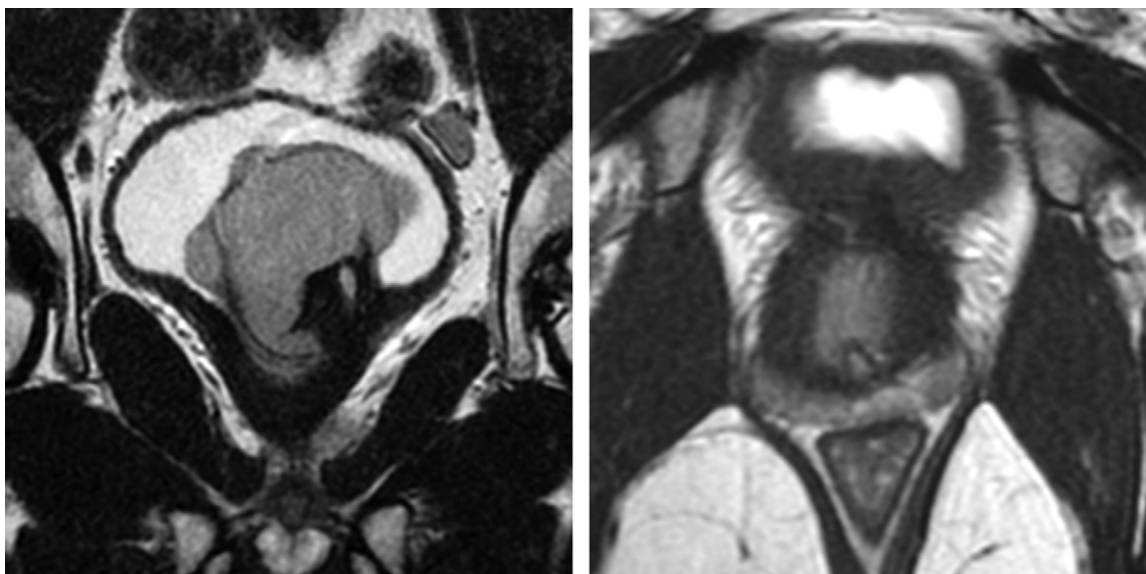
(a) Coronal and (b, c) axial fast spin-echo T2-weighted MR images of the pelvis, with b being superior to c.
